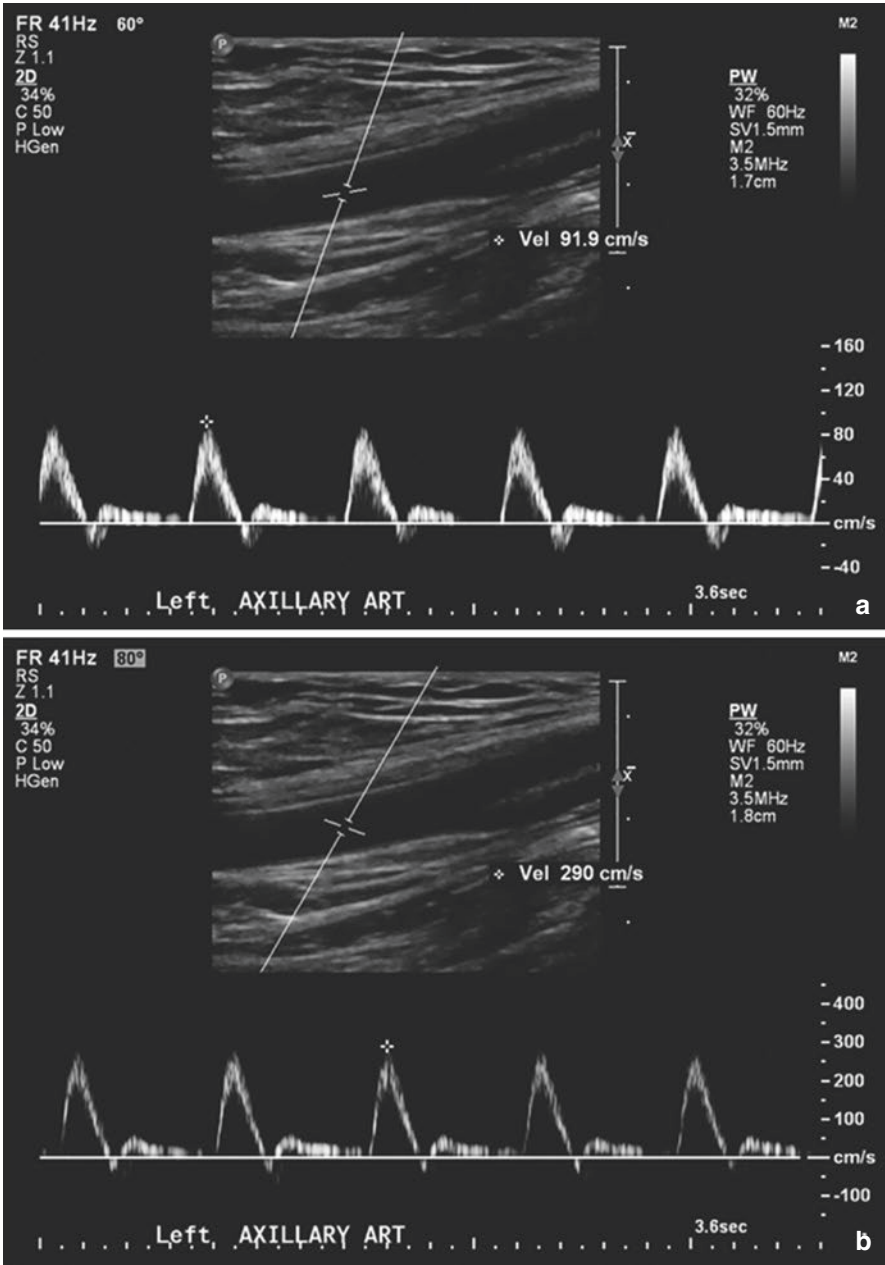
The Doppler angle can be chosen by the ultrasound user. In (a), the Doppler angle is set to 60 degrees (upper left corner). This gives a velocity measurement of 91.9 cm/s. In (b), the Doppler angle is incorrectly chosen at 80 degrees. This gives a velocity of 290 cm/s which suggests a possible stenosis in the axillary that is being interrogated. In order to optimize and standardize vascular ultrasound reporting, an angle as close as possible to 60 degrees is chosen
